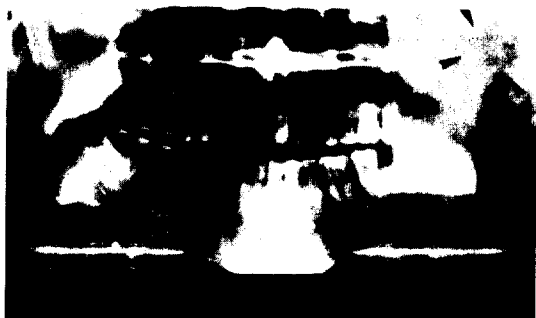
Preoperative panoramic radiograph of case 1. Note the enlarged left condylar head.
